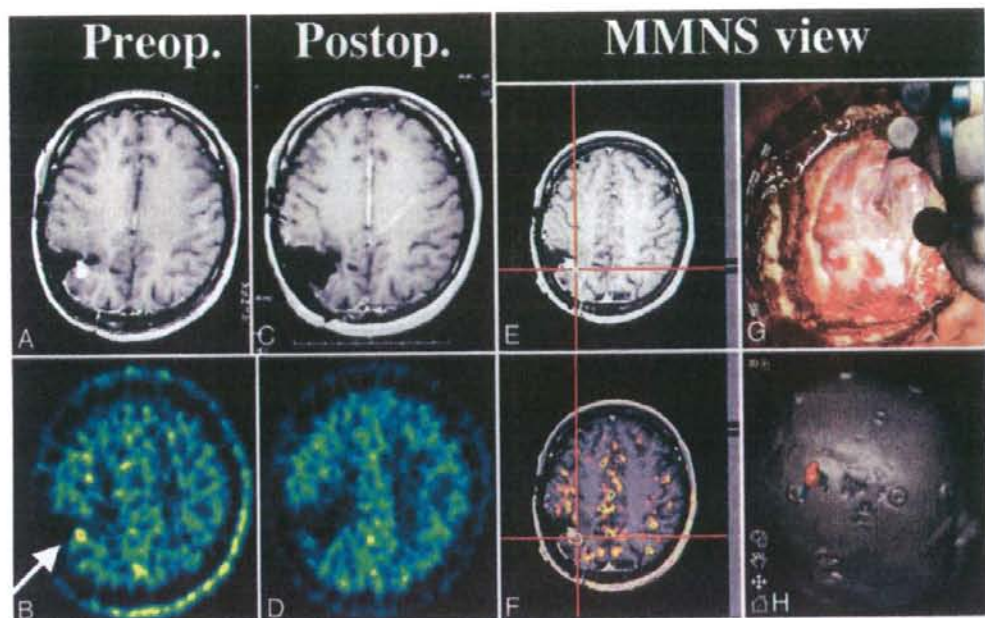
Images obtained in a 35-year-old woman with recurrent anaplastic astrocytoma. The patient had already undergone 2 operations, conventional irradiation, and chemotherapy before the multimodal navigation system (MMNS)-guided removal was performed. Preoperative MR imaging (A) and MET-PET (B) showed a similar spotty lesion in the right parietal lobe (arrow). In contrast, the fusion image (F) and a 3D reconstructed image (H) revealed a regional discrepancy between the enhanced spot on MR imaging and the uptake peak of the MET-PET image (the latter was located in a deeper portion than the former). Pathological examination revealed that the Gd-enhanced area mainly consisted of granulation, and that the distribution of tumor tissue corresponded closely with the area of elevated MET uptake. A covering of thickened arachnoid membrane and connective tissue over the cortical membrane resulted in a loss of the normal cortical structure (G). Regardless, the multimodal navigation system clearly depicted the lesion with elevated MET uptake (F). The patient is free from symptoms and recurrence 4 years after the operation (C and D).
